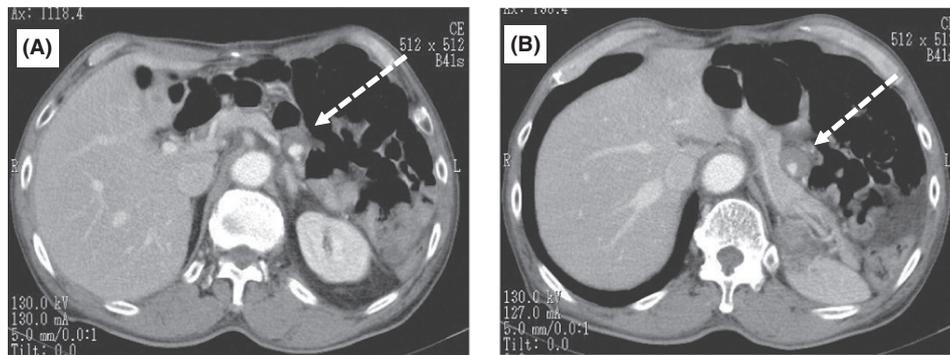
Preoperative enhanced abdominal computed tomography (CT) incidentally revealed two middle colic artery aneurysms. (A) The proximal aneurysm measured 20 × 19 mm and, (B) the distal aneurysm measured 23 × 21 mm.
